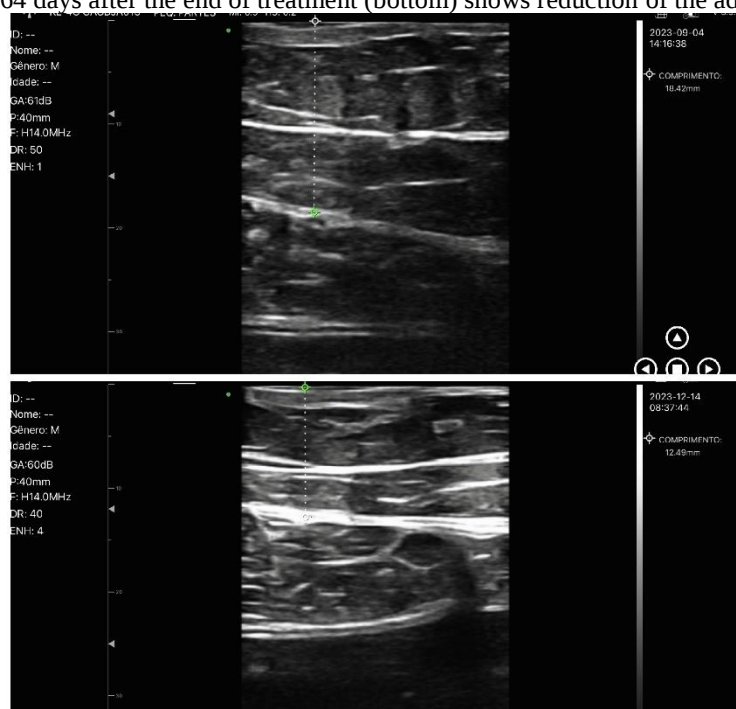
Ultrasound of representative assessment of the thickness of the central lower layer. Fat thickness at baseline (top) and 64 days after the end of treatment (bottom) shows reduction of the adipose layer.
